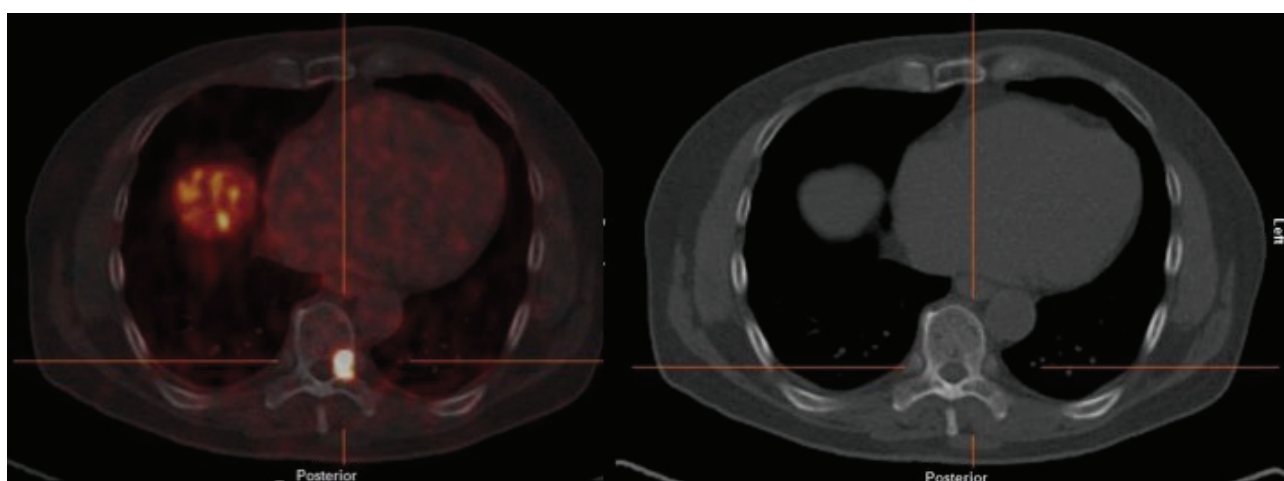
PSMA PET can detect bone metastases in PCa without changes on CT.
